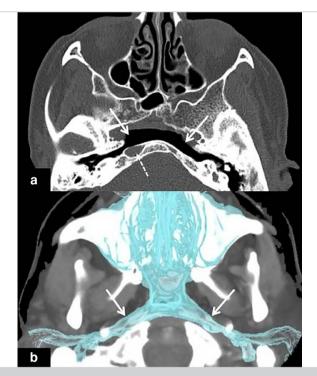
a) On the axial unenhanced computed tomography image, both Eustachian tubes are observed to be wider than normal and with a horizontal course (white arrows), and both carotid canals are not observed. In addition, in the clivus localization, a bone defect in which the aberrant internal carotid artery course is noted (dotted white arrow). b) 3D-volume rendering computed tomography fusion image shows patulous Eustachian tubes (white arrows) connecting the nasopharynx and middle ear bilaterally
